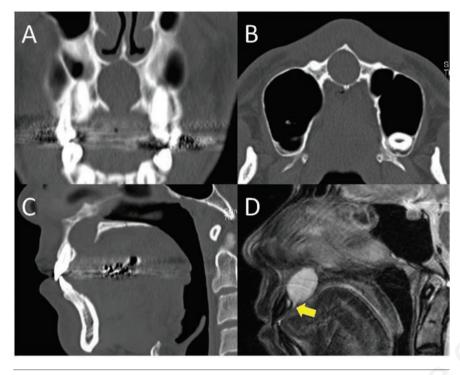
Preoperative computed tomography scans and T2-weighted magnetic resonance image. Coronal (A), axial (B) and sagittal (C) views demonstrating the radiotransparency at the upper maxillary midline, and a homogeneous high intensity area in the nasopalatine duct (D). The nasopalatine duct (arrow) is observed at the bottom of the cyst.
